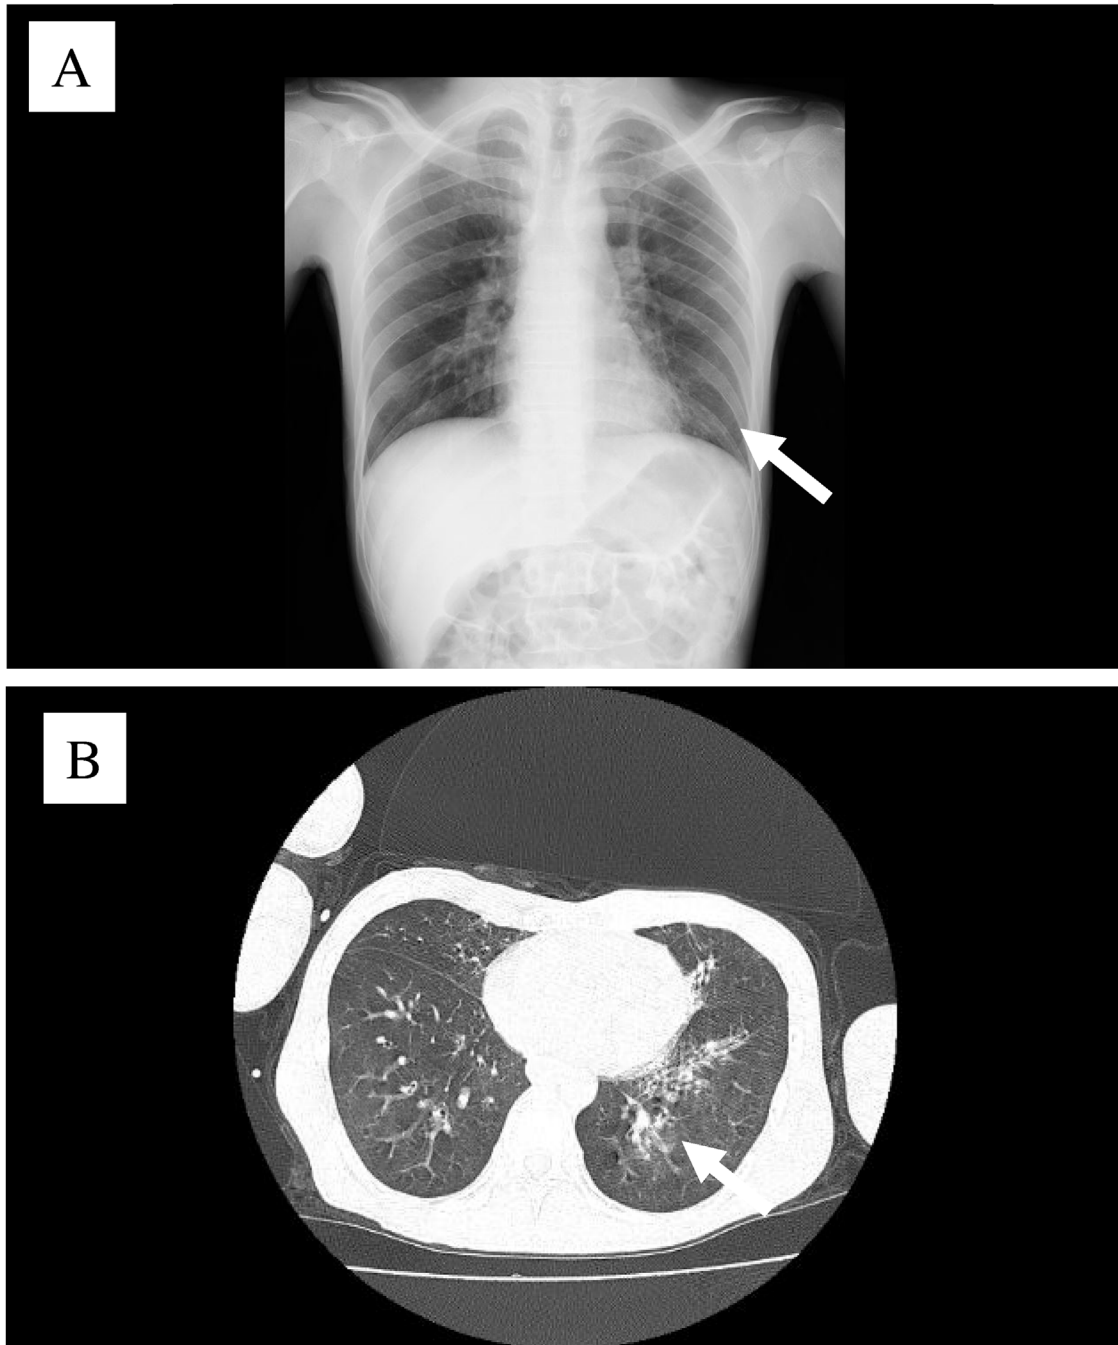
Chest X-ray (A) and computed tomography (B) findings of patient 2. Infiltrative shadows in left lower lung suggest bronchopneumonia (arrows).
